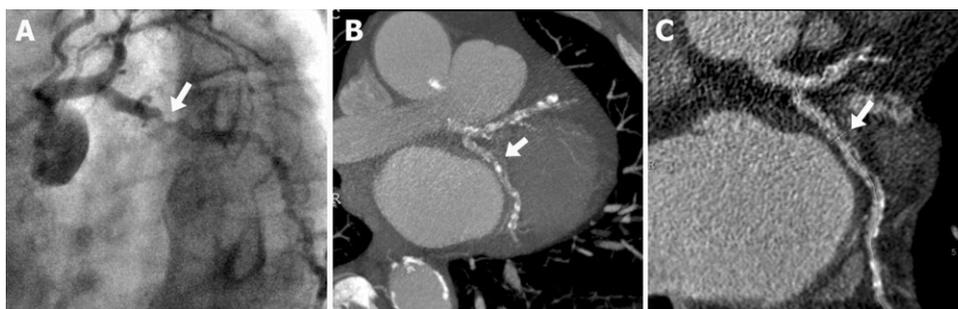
Study patient with severe stenosis in the proximal left circumflex coronary artery shown on (A) cine fluoroscopic view, (B) MDCT maximum intensity projection image, and (C) MDCT curved multiplanar reconstruction image. Multidetector computed tomography underestimated stenosis severity due to limited image quality caused by this patient’s obesity, dysrhythmias, and coronary calcifications.
